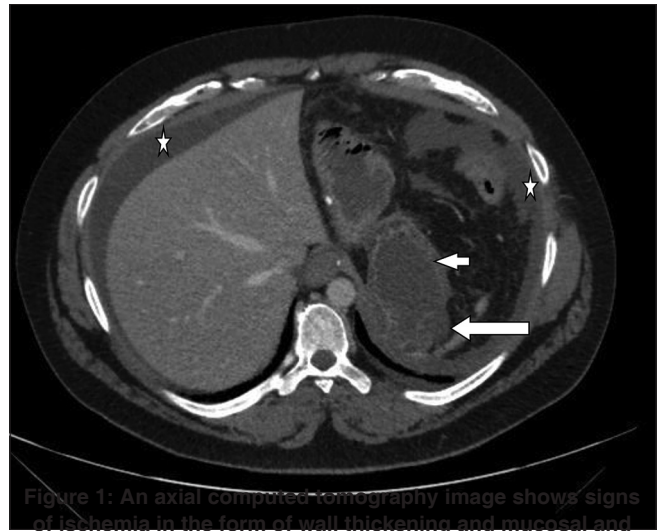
An axial computed tomography image shows signs of ischemia in the form of wall thickening and mucosal and serosal enhancement, with submucosal edema in the bypassed part of the stomach (small arrow). An indistinct margin of the stomach wall can be seen posteriorly with an adjacent fluid pocket in keeping with perforation (large arrow). Free fluid is seen in the upper abdomen (star)
